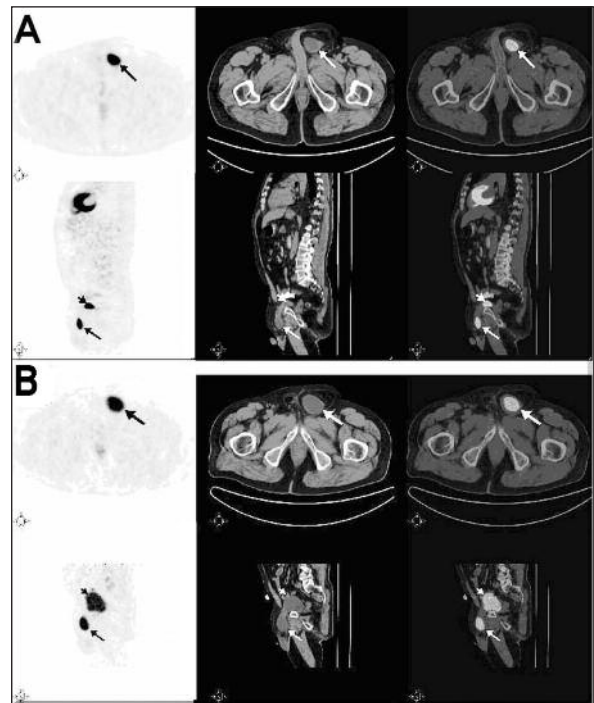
A. Axial and sagittal FDG PET/CT images demonstrate a hypermetabolic focus in the left inguinal region (long arrows). B. Delayed FDG PET/CT images show some enlargement of this FDG accumulation. Sagittal images also reveal the association between the focal activity in the inguinal region (long arrows) and the bladder (short arrows).
